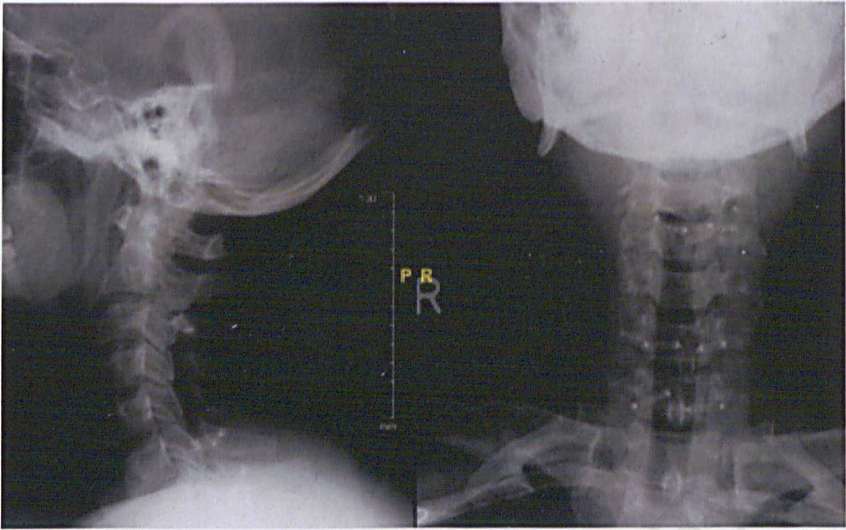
Cervical C3-6 laminoplasty, tiny titanium plates hold the C3, C4, C5 and C6 lamina to the parent vertebra (cervical radiograph – lateral and AP view)
